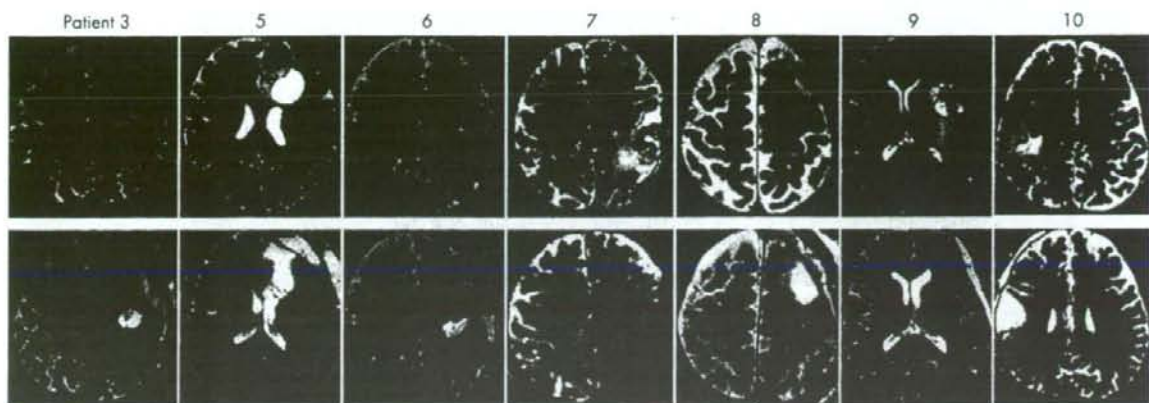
Upper: preoperative T2 weighted MRI in patient Nos 3, 5, 6, 7, 8, 9 and 10, with brain tumours showing a hyperintense area that is close to the pyramidal tracts (red), identified by fibre-tracking. Lower: postoperative T2 weighted MRI demonstrated the extent of tumour removal. Postoperative fibre-tracking in patient Nos 3, 6 and 9 revealed preservation of the pyramidal tracts (red).
